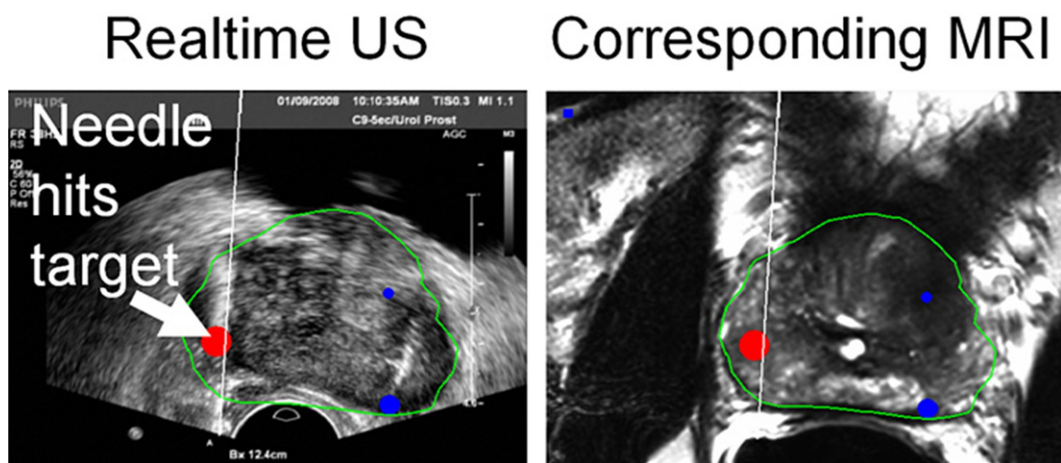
Combined real-time US and corresponding multiplanar reconstruction of co-registered preprocedural MRI with superimposed MRI based prostate segmentation (green outline) and MRI identified targets (red and blue areas).
